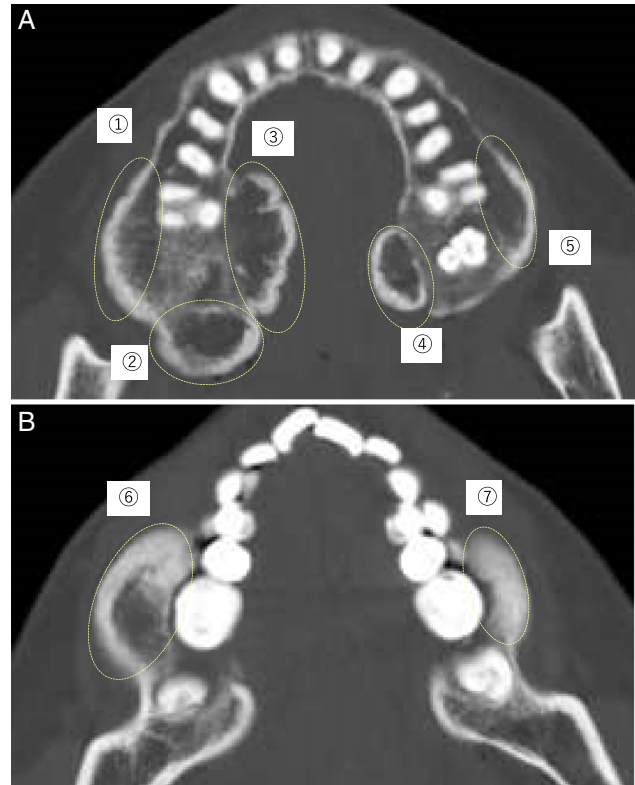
Preoperative examination. (A) Computed tomography reveals lesions at seven locations with Hounsfield Units equivalent to that of the maxilla (A) and mandible (B). (1) 26×11×10 mm, (2) 16×15×13 mm, (3) 26×12×12 mm, (4) 15×13×8 mm, (5) 15×12×6 mm, (6) 26×16×15 mm, (7) 20×13×9 mm.
